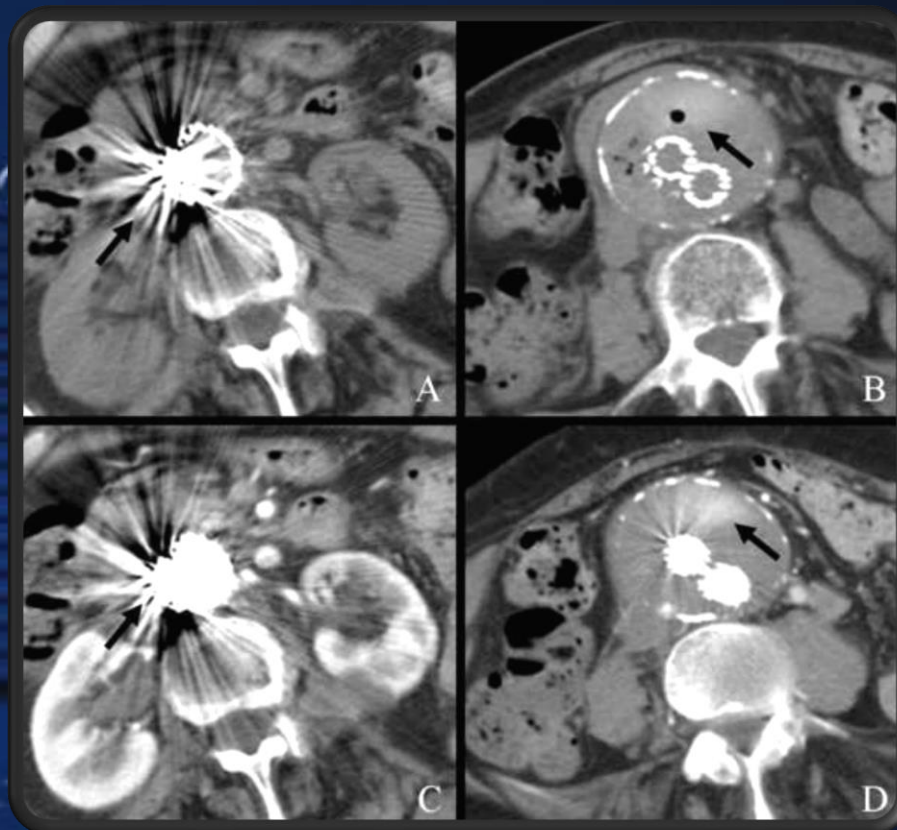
CTA after TCEE of type Ib endoleak. (A,B)Axial scan without contrast medium shows embolizing coil in the sealing zone and stable contrast medium with gas bubbles (arrow) inside the aneurysm sac, as a result of embolization treatment. (C,D) Scan in arterial phase shows coils and complete exclusion of the aneurysm sac.
